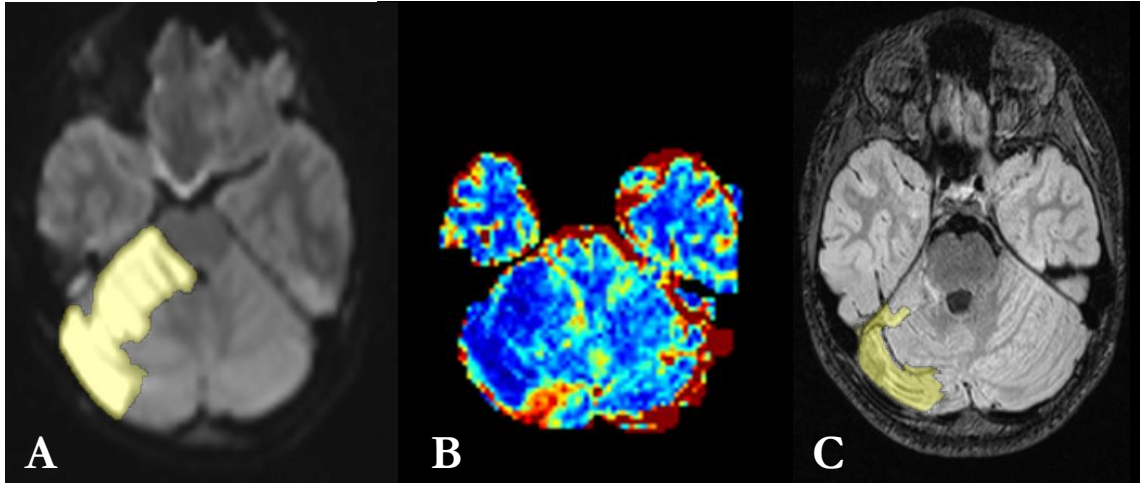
Case study of a 9-year-old boy with a cryptogenic cerebellar stroke associated with poor cognitive outcome 4 - 6 years post-stroke (A) DWI showing manually segmented infarct (B) RAPID relative CBF map showing area of hypoperfusion (C) T2 FLAIR showing chronic infarct.
